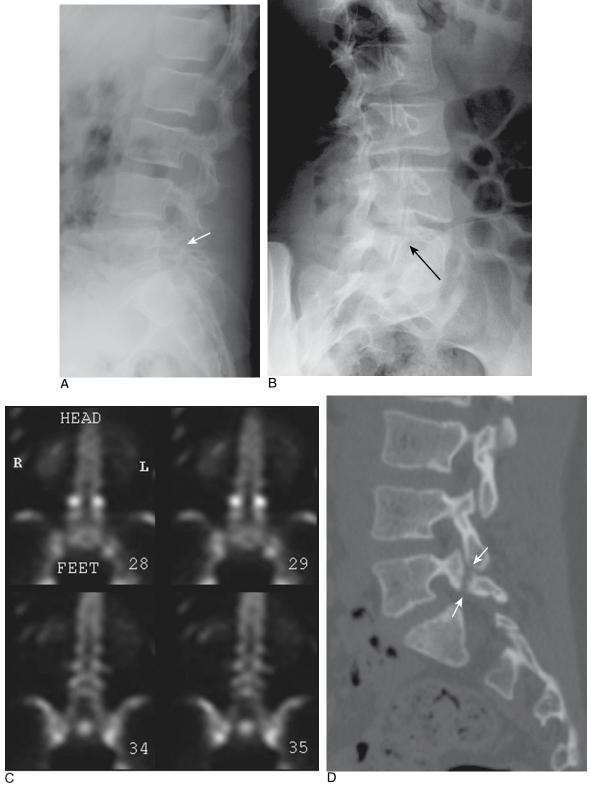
A. Radiograph of spondylolysis with arrow pointing to lysis of pars interarticularis. B. Oblique view in the same patient. C. SPECT scan demonstrating L5-S1 spondylolysis. D. Computed tomography with arrows demonstrating spondylolysis.
